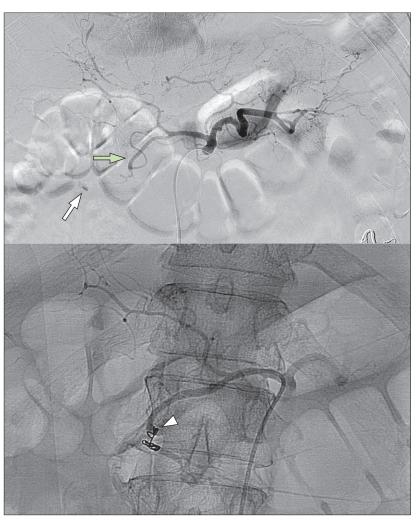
Radiographs showing active contrast extravasation (green arrow) from a branch of the gastroduodenal artery (white arrow) during angiography, and fibre coils that were deposited to the artery to stop bleeding (white arrowhead)
